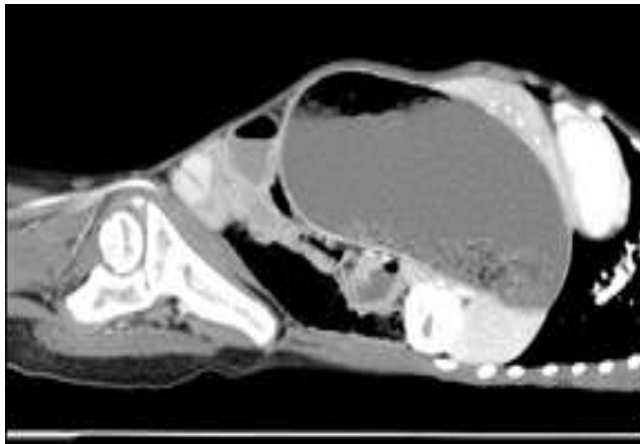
CT scan, showing dilated stomach reaching up to the pelvis
